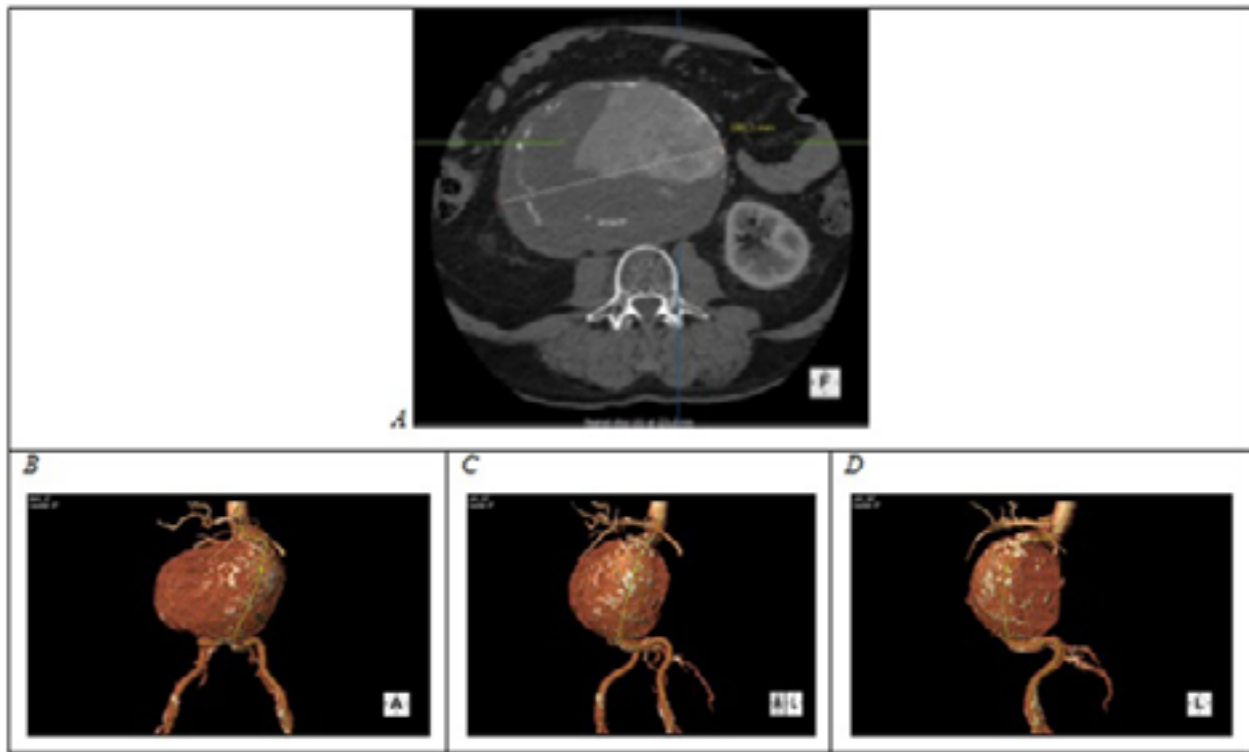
Preoperative computed tomography angiograms of the giant infrarenal aortic aneurysm A) on the axial section B-D) three-dimensional reconstruction from different views.
